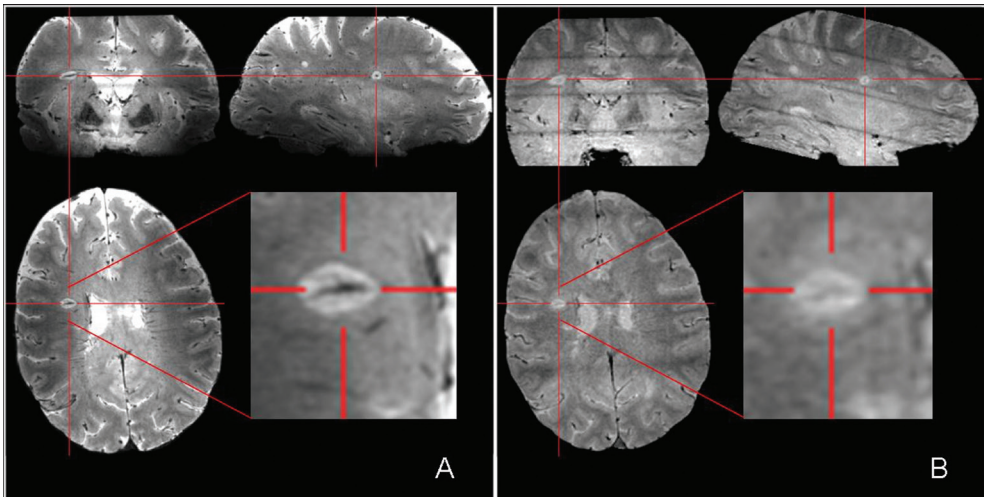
7T T_2^* -weighted MRI shows more detail of central veins in MS lesions than 3T. T_2^* images of a patient with MS showing a large lesion with a perivenous orientation. On the 7T image (A) the vein can be seen in more detail than on the equivalent 3T image (B). Image courtesy of Dr. Emma Tallantyre.
